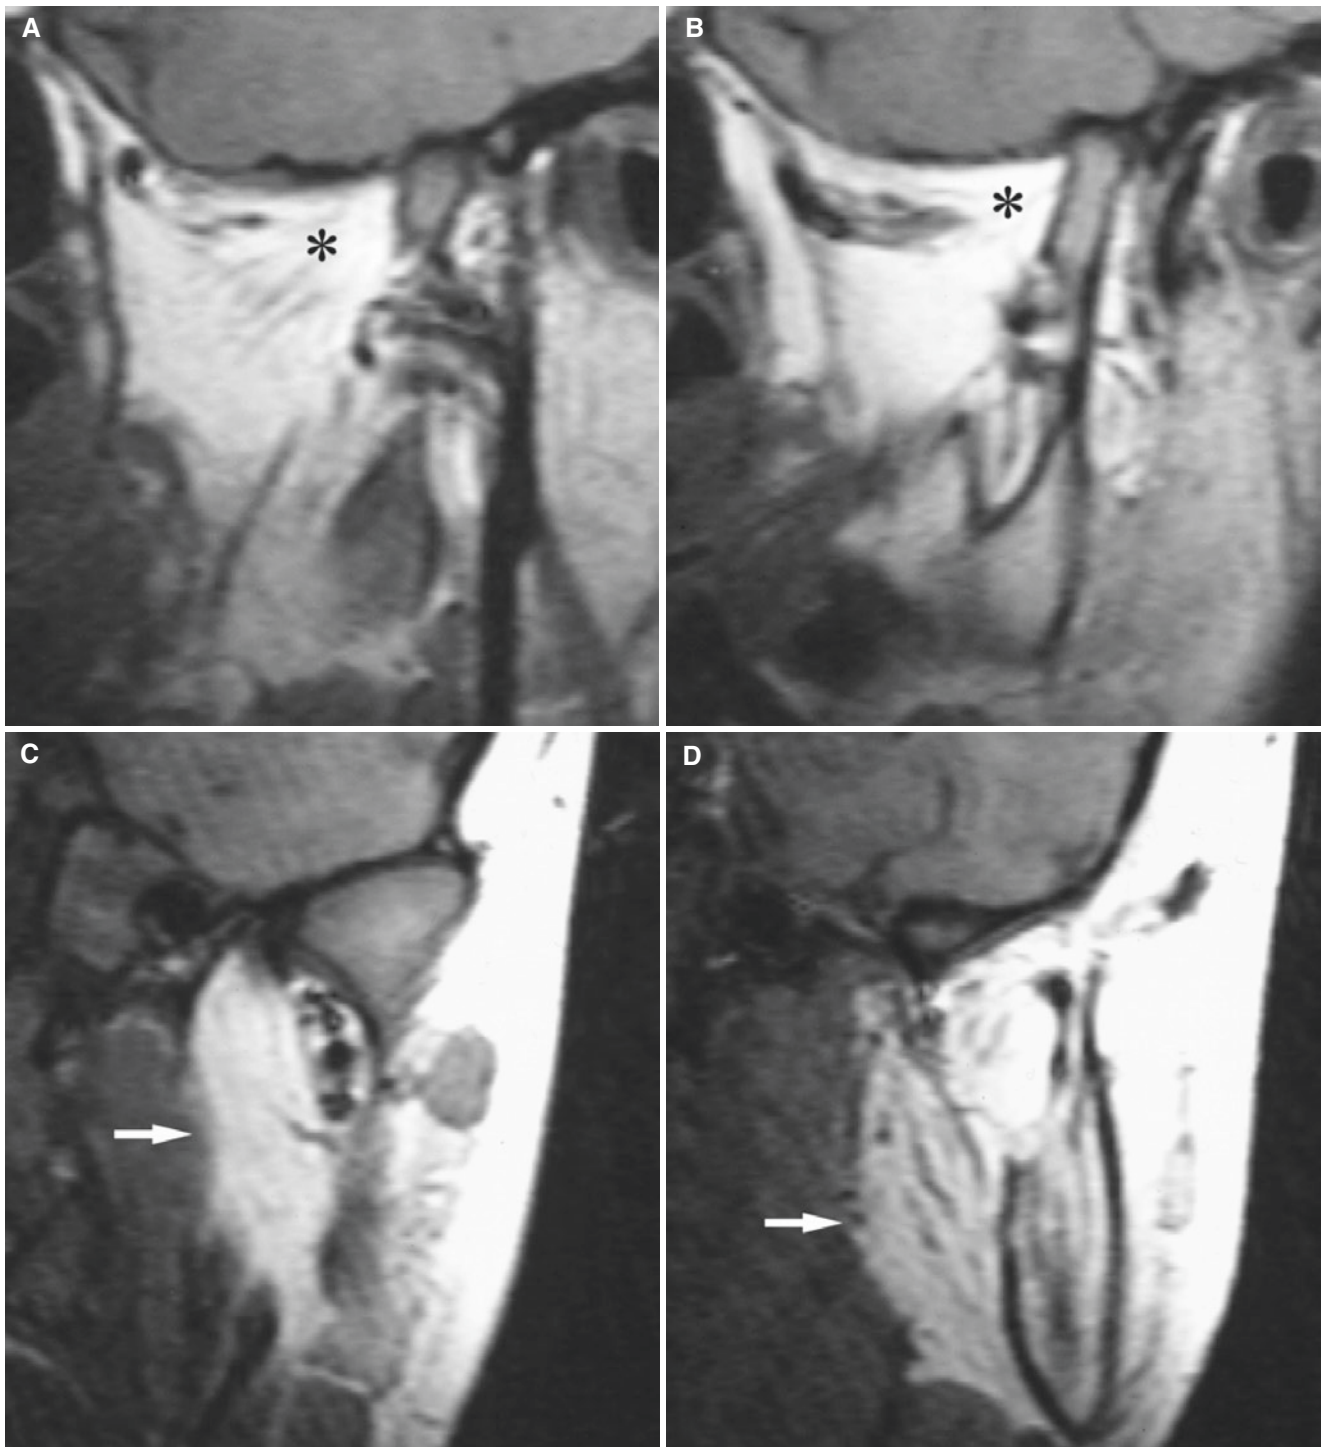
Arthrogryposis multiplex congenita; 9-year-old male with micrognathic growth, anterior open bite, and severely limited mandibular motion with chewing and articulation problems. (A) Oblique sagittal T1-weighted MRI, medial aspect of mandibular condyle, shows lateral pterygoid muscle atrophy with fatty replacement (*asterisk*). (B) Oblique sagittal T1-weighted MRI, midsection of mandibular condyle, confirms
